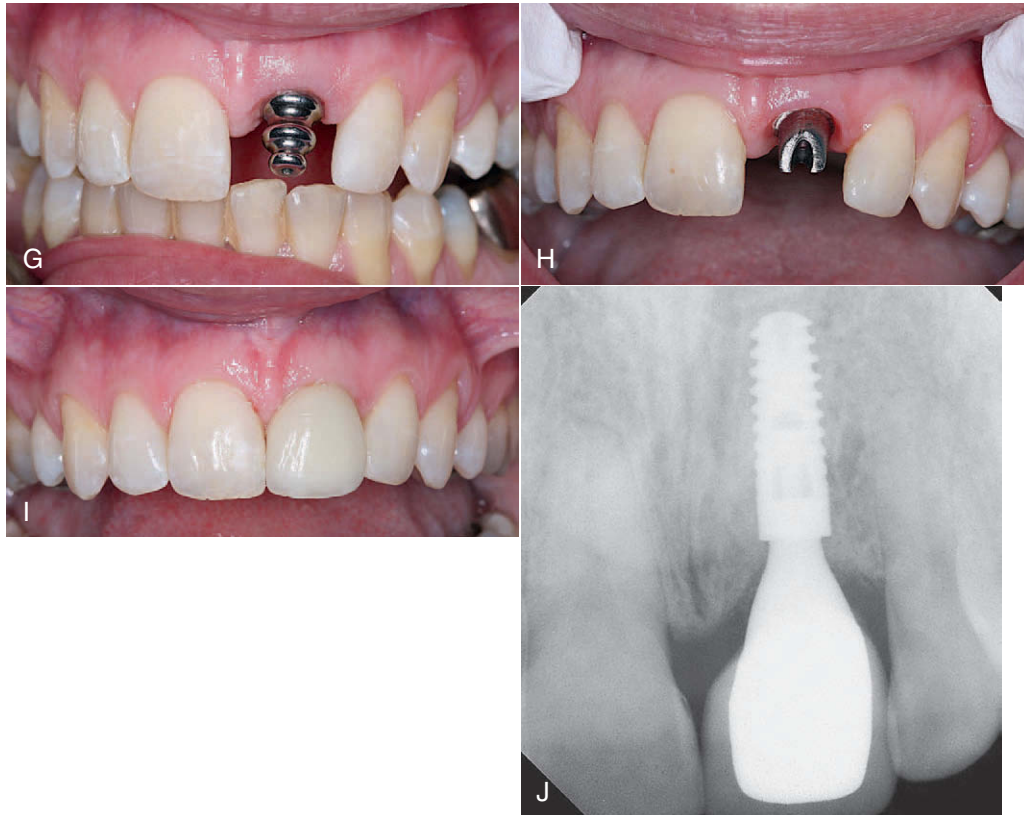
cont'd • G, Impression coping is in place. H, Abutment is seated 4 months after extraction. I, Final crown is seated; clinical view shows excellent soft tissue contours. J, Radiograph shows excellent bone height.
